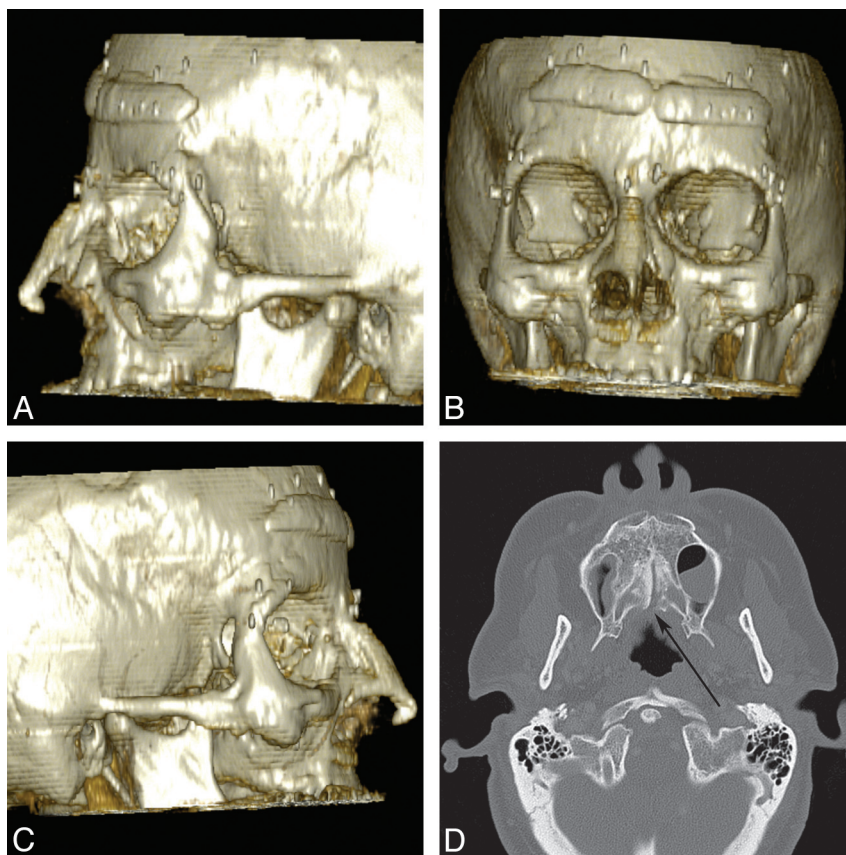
A 47-year-old woman with Stickler syndrome. A–C, 3D bony reconstructions show a flat midface with a depressed nasal bridge, short nose, anteverted nares, and zygomatic hypoplasia. Reconstructive and cosmetic hardware and implants are present. D, Axial CT scan shows incomplete fusion of the palatal bones with a posterior submucosal cleft (arrow).
